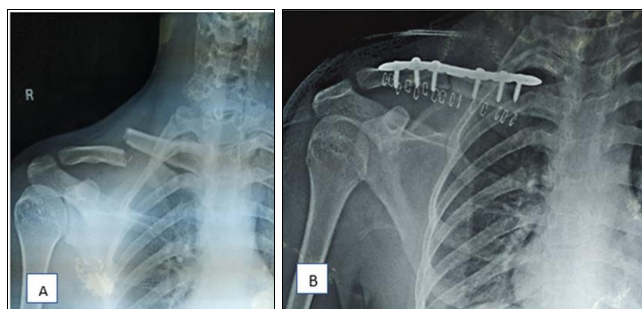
Patient treated surgically A) Initial radiograph of the fracture at presentation B) Radiograph in immediate post operative period
